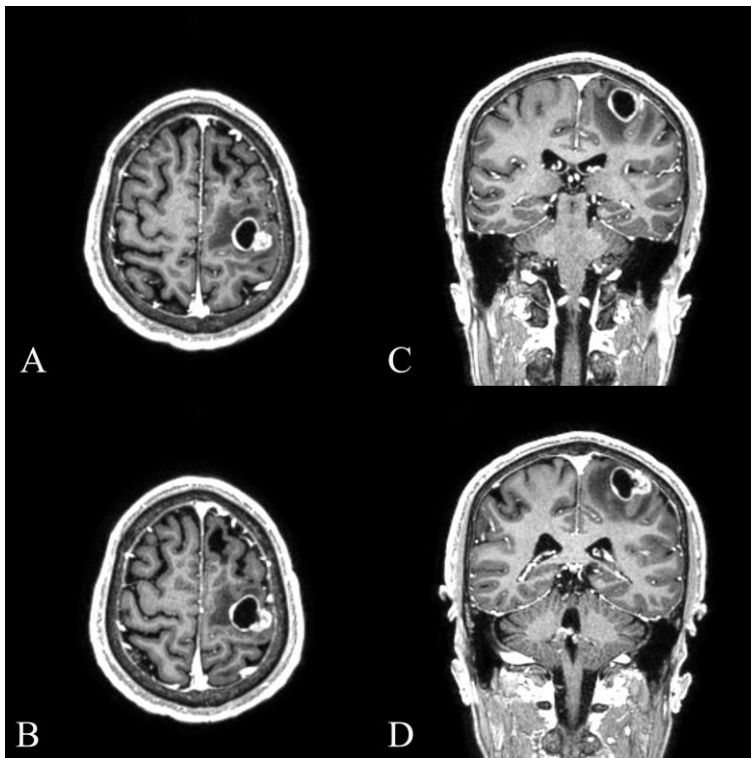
MRI (enhance) revealed 2.4 x 2.0 2.5 cm sized necrotic mass with peritumoral edema was located at left hand knob of primary motor cortex. A, B: axial images of brain, C, D: coronal images of brain
